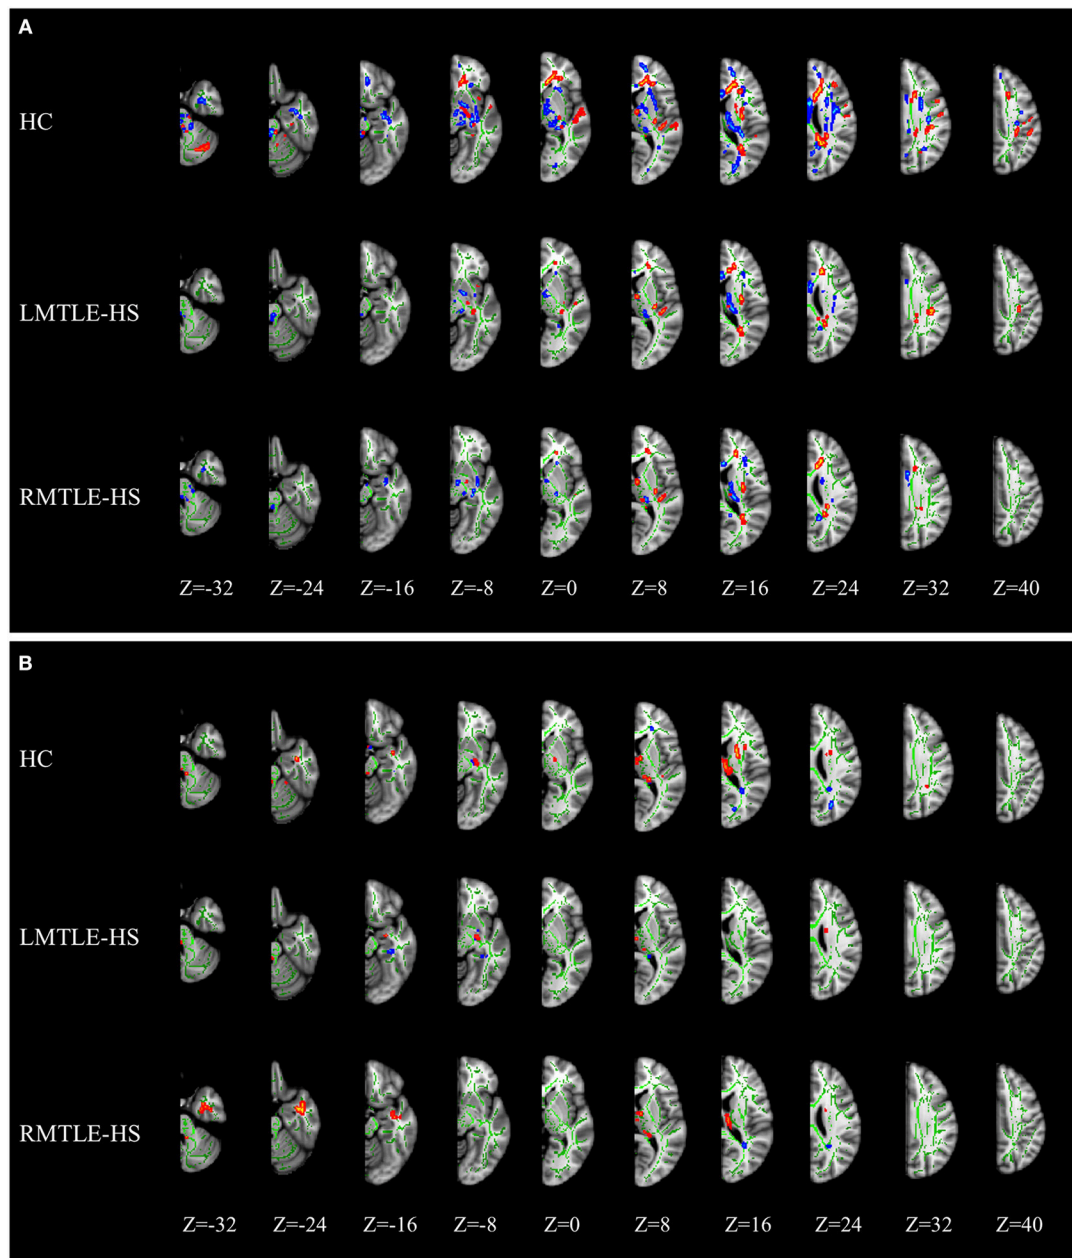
MRI images of significant tract-based spatial statistics (TBSS) clusters of white matter asymmetry in healthy controls, patients with left mesial temporal lobe epilepsy with hippocampal sclerosis (LMTLE-HS) and patients with right MTLE-HS. (A) Represents fractional anisotropy (FA) and (B) represents mean diffusivity (MD). Results are presented on the left hemisphere of the symmetric TBSS skeleton (depicted in green). Rightward asymmetry that was defined as having a larger FA/MD value of the right brain (R) than the left (L) ($R > L$) depicted in blue-light-blue and leftward asymmetry ($L > R$) in red-yellow.
